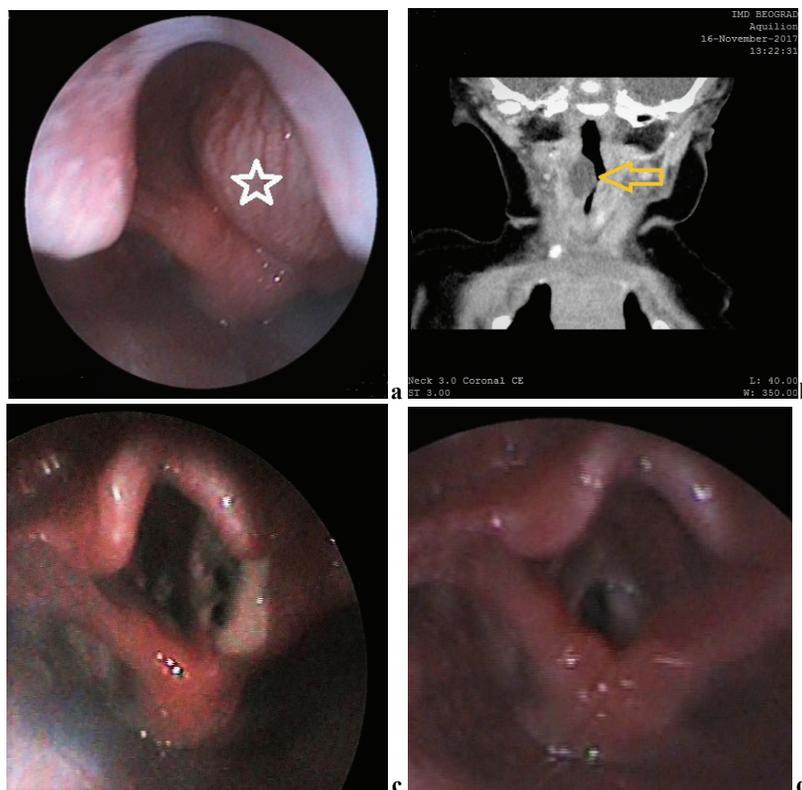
(a) Endoscopic view of the congenital laryngeal cyst before surgery. Note the presence of laryngeal cyst (asterisk inside) on the right ventricular fold; (b) coronal plane of the computed tomography scan of the throat. Note the presence of a laryngeal cyst on the right lateral wall of the larynx (arrow head); (c) endoscopic view, 7 days after excision of the cyst from the right ventricular fold. Note the presence of two breaches on the inner surface of the larynx; (d) endoscopic view in the same patient 12 months after surgical treatment. Note the absence of breaches.
